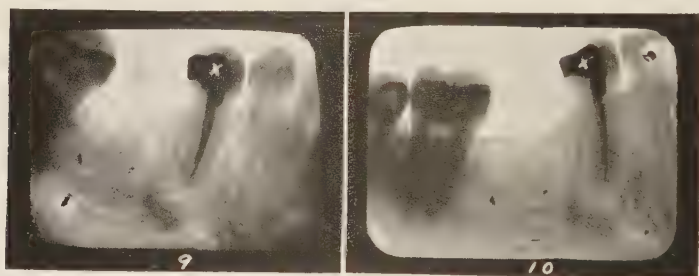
Case of Miss S. Radiograph No. 9 shows the condition eleven months after filling the pulp canal. Radiograph No. 10 shows condition nearly one year and one month after filling root canals.
